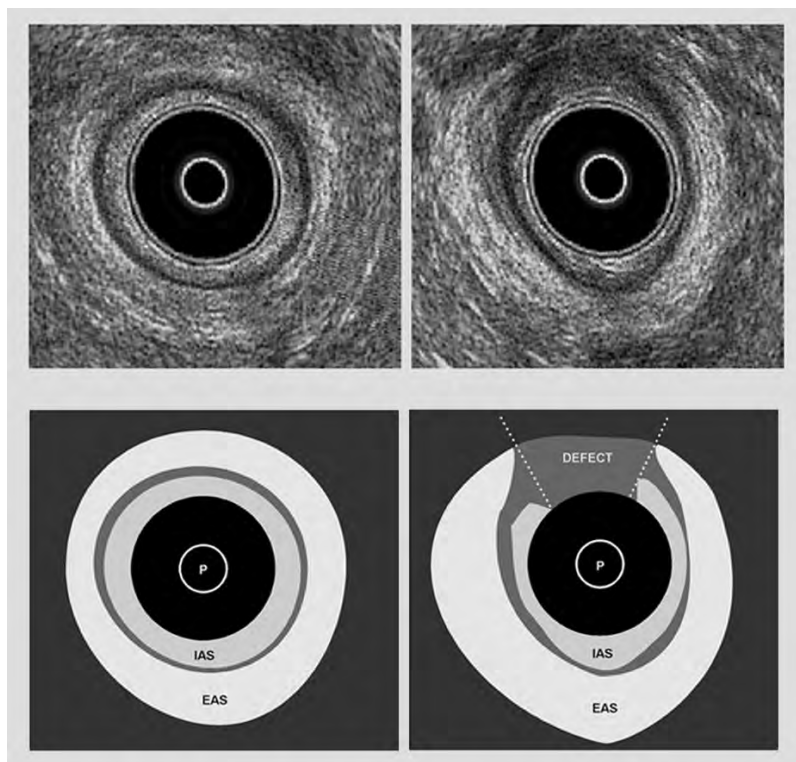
Endo-anal ultrasound
